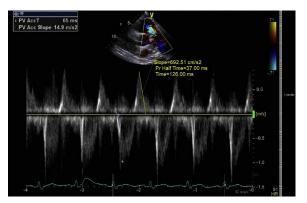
Doppler velocity trace depicting rapid deceleration rate, as shown by the steep PR slope, with extension into late diastole, which is indicative of severe PR. *PR*, Pulmonic regurgitation.
